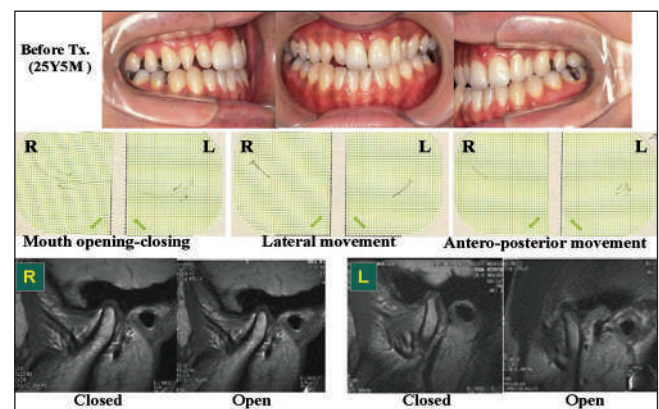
Treatment of a patient with myalgia of the masticatory muscles top: Occlusion before treatment, middle: Condylar movement trajectory to show limited movement of the condyle, Bottom: Magnetic resonance images to show normal status of intra-articular pathology with articular disk on the condyle
